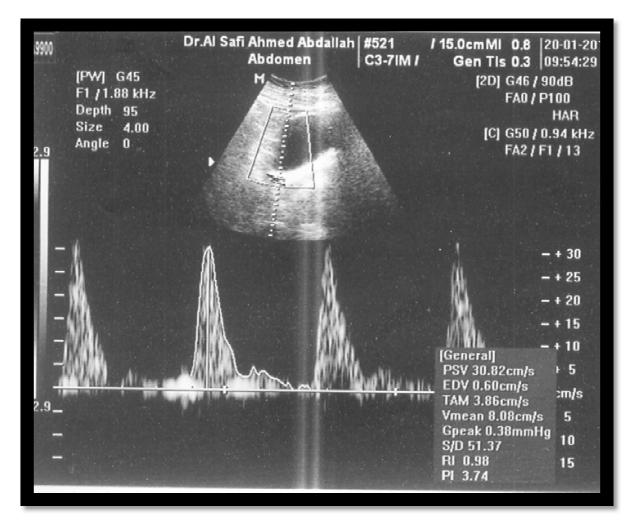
Color Doppler scan for 39 old patients with a history of (RPL) showing complete abortion.
